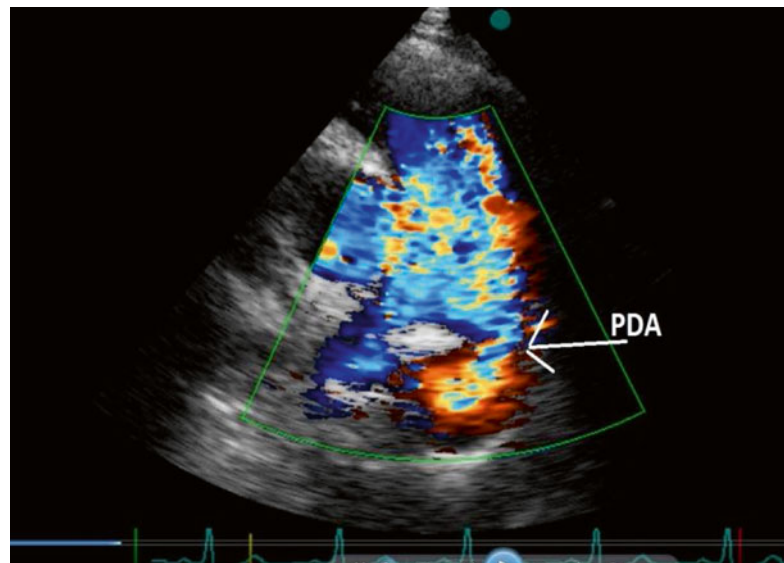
Color Doppler flow imaging in parasternal short-axis view showing high-velocity continuous turbulent flow entering to the pulmonary artery (PA) near the LPA origin
